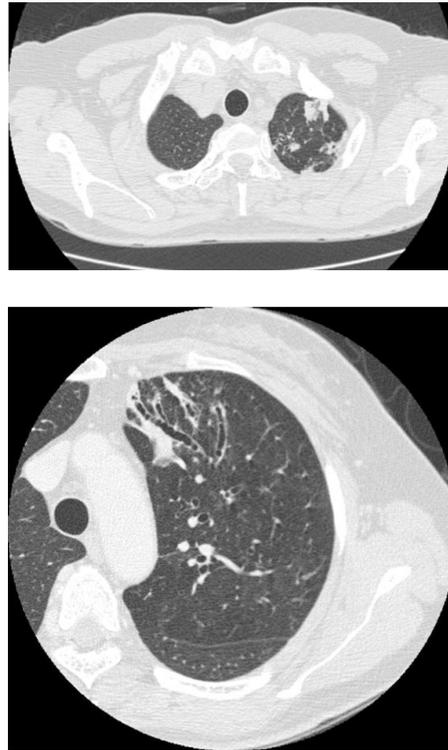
Chest CT showed nodular and linear shadows with bronchiectasis and small cavities in the left upper lobe and lingula.
